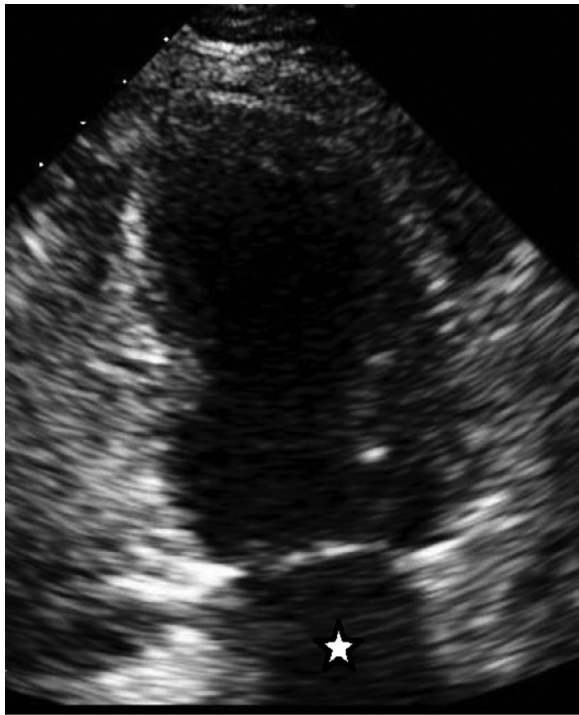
Subcostal, 2-chamber echocardiographic view. Diffuse low-level intraluminal echoes are demonstrated, consistent with “smoke” artefact in the markedly dilated LA (white star).
